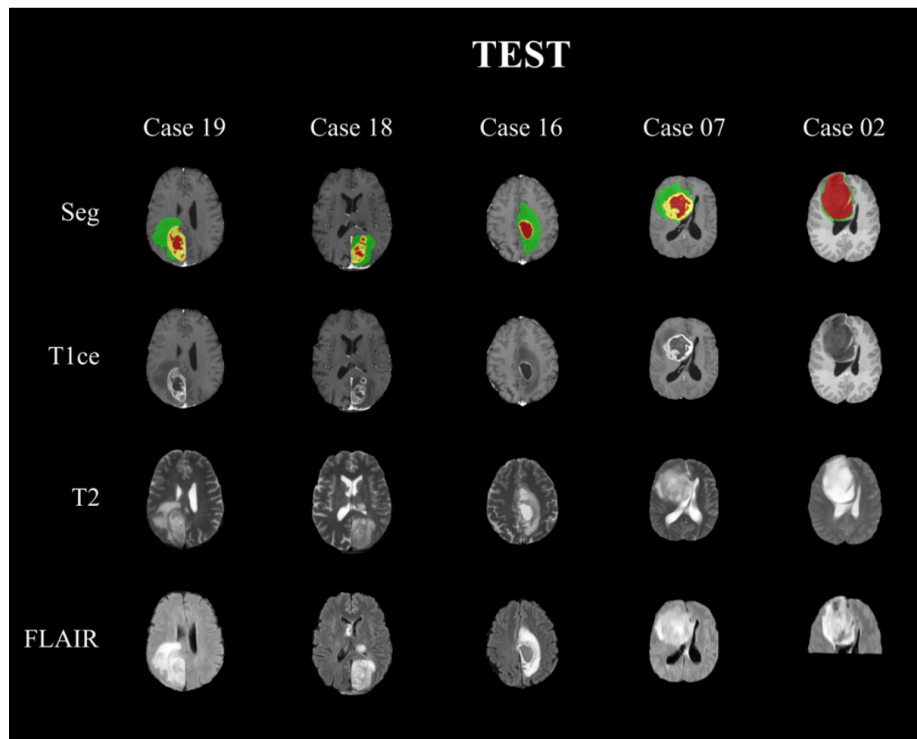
Examples of glioma segmentation of 5 cases from the test set. First row shows the segmentation performed by the ONCOhabitats model over the T1ce sequence. Second, third and fourth rows show the T1ce, T2 and FLAIR sequences respectively.
